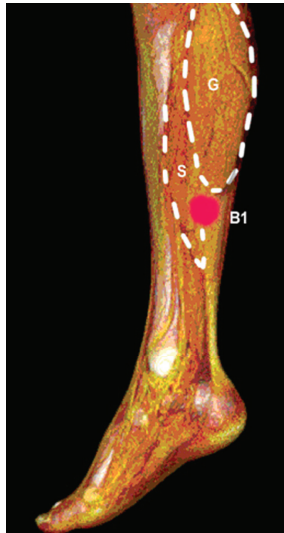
Point B1 (virtual dissection of the leg with a CT scan and a 3D reconstruction without contrast medium. G: medial gastrocnemius muscle; S: soleus muscle).
